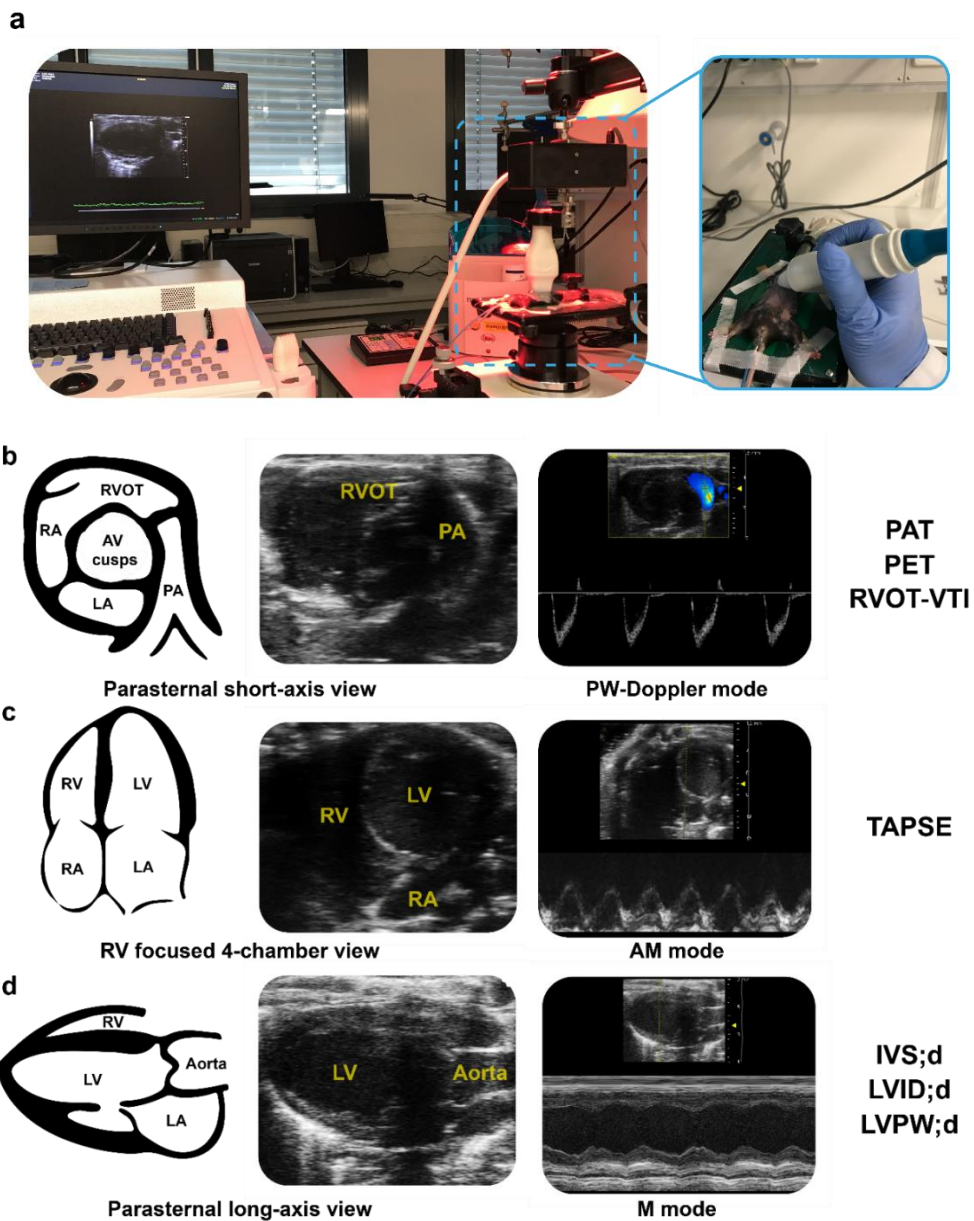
Non-invasive transthoracic echocardiography. a, A photo of the Vevo® 2100 high-resolution Imaging System taken during a measurement. b, Representative images acquired from parasternal short-axis view and PW-Doppler mode. c, Representative images acquired from RV focused 4-chamber view and AM mode. d, Representative images acquired from parasternal long-axis view and M mode.
